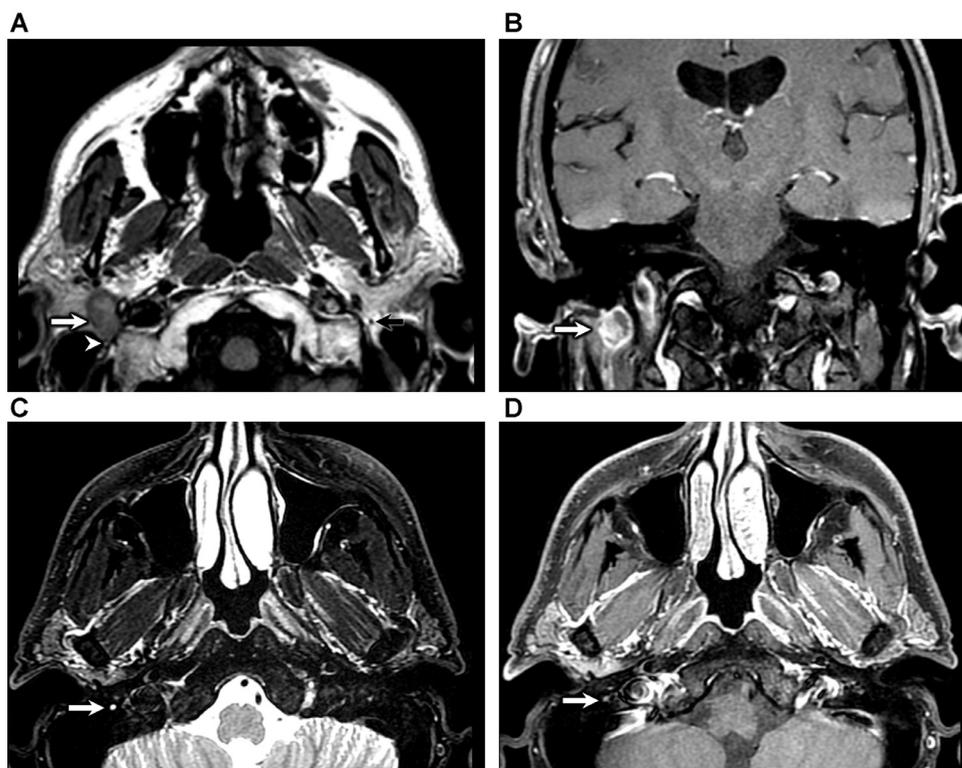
Malignant perineural tumor spread to the facial nerve from a parotid mass in a 55-year-old male with facial paralysis. (A) Axial T1 weighted image without contrast. There is a T1 hypointense round mass in the right parotid gland (white arrow) extending to the right stylomastoid foramen (white arrowhead), effacing the right facial nerve. Compare this to the normal left facial (black arrow) nerve seen surrounded by fat just after exiting left stylomastoid foramen. (B) Coronal T1-weighted postcontrast fat-saturated images confirms a solid enhancing mass (white arrow) in the deep right parotid gland just below the stylomastoid foramen. (C) The distal vertical segment of the right facial nerve (white arrow) is abnormally T2 hyperintense and enlarged with (D) asymmetric enhancement (white arrow) concerning for malignant perineural tumor spread, which was confirmed surgically, from a primary parotid mucoepidermoid carcinoma.
